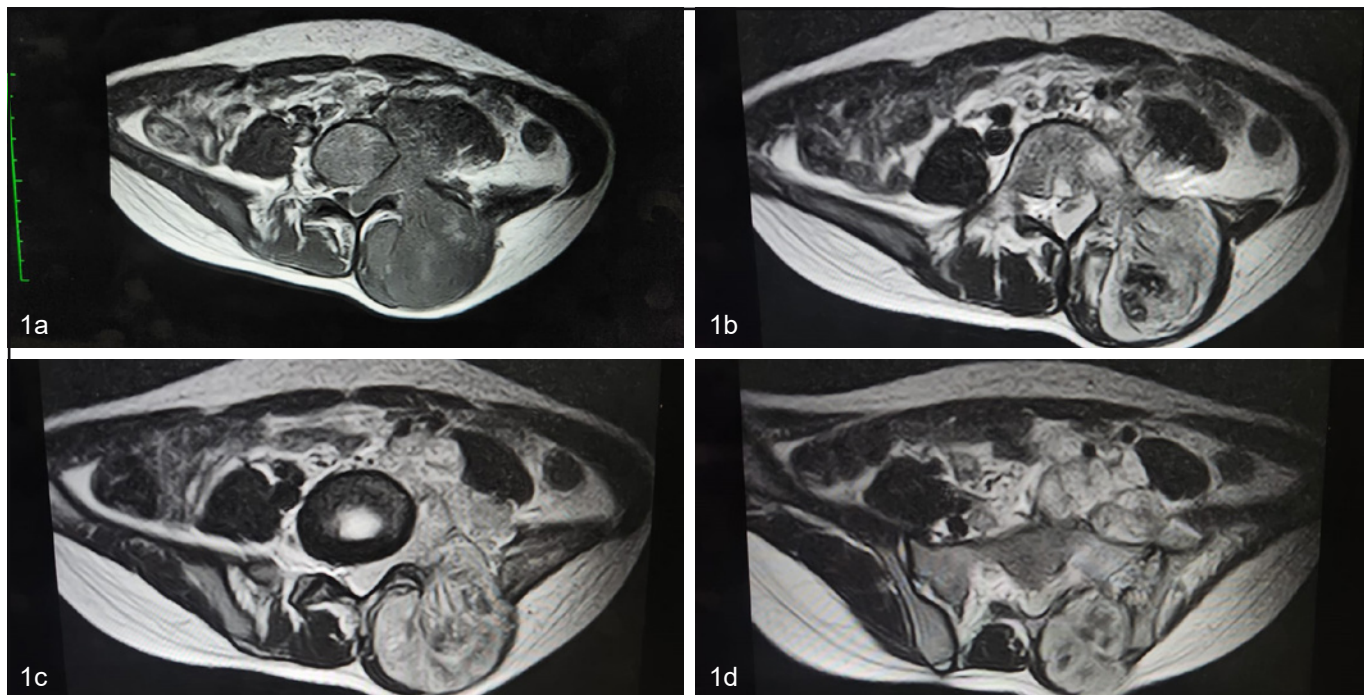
MRI T2 images axial cuts. An abnormal signal intensity mass showing areas of necrosis is seen in the left paraspinal region showing infiltration in the left paraspinal muscle at the level of L3/L4 vertebral bodies which was infiltrating into the left exit foramina and left psoas muscle and posterior abdominal and into the left exit foramina at the level of L4/5 and in the spinal canal, continuing up to the sacral region of about the level of S3.
